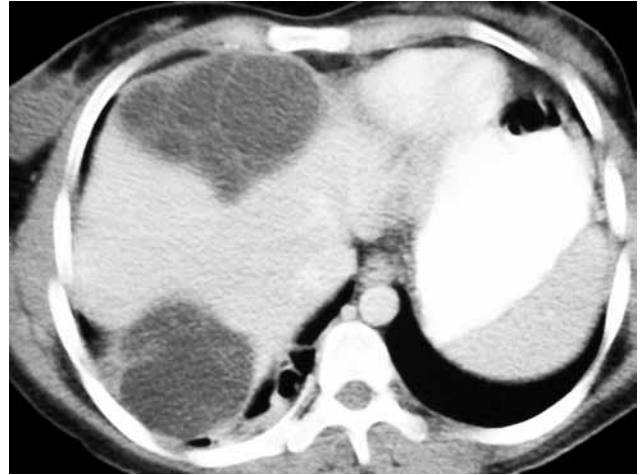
Computed tomographic image of the second case showing the multiloculated, hypodense, smooth-bordered cystic appearance at the fourth and eighth segments of the liver. No distinction could be made between the exophytic, septated, hypodense, smooth-bordered cystic area at the border and the liver since it was situated at posteriorly. It also shows the atelectatic area at the posterior segment of the lower lobe of the right lung.
